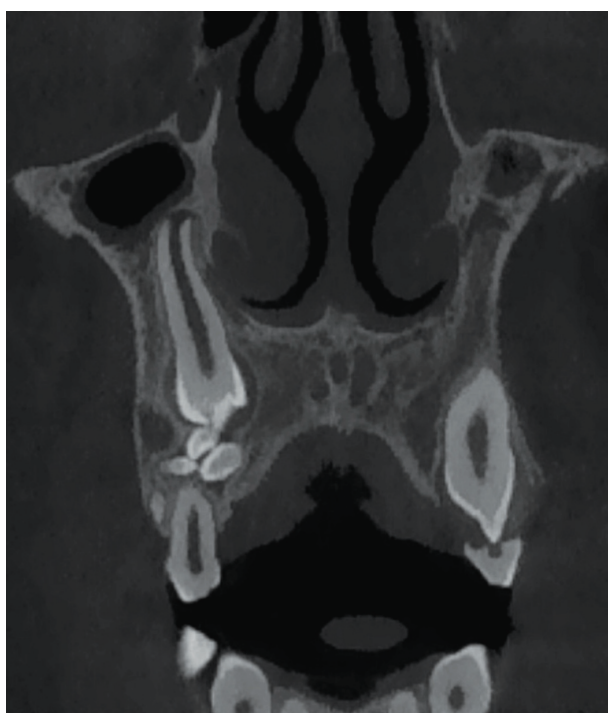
Coronal CBCT image showing the bucco-palatal relationship of a compound odontoma in the right maxilla of an 11-year-old female.
